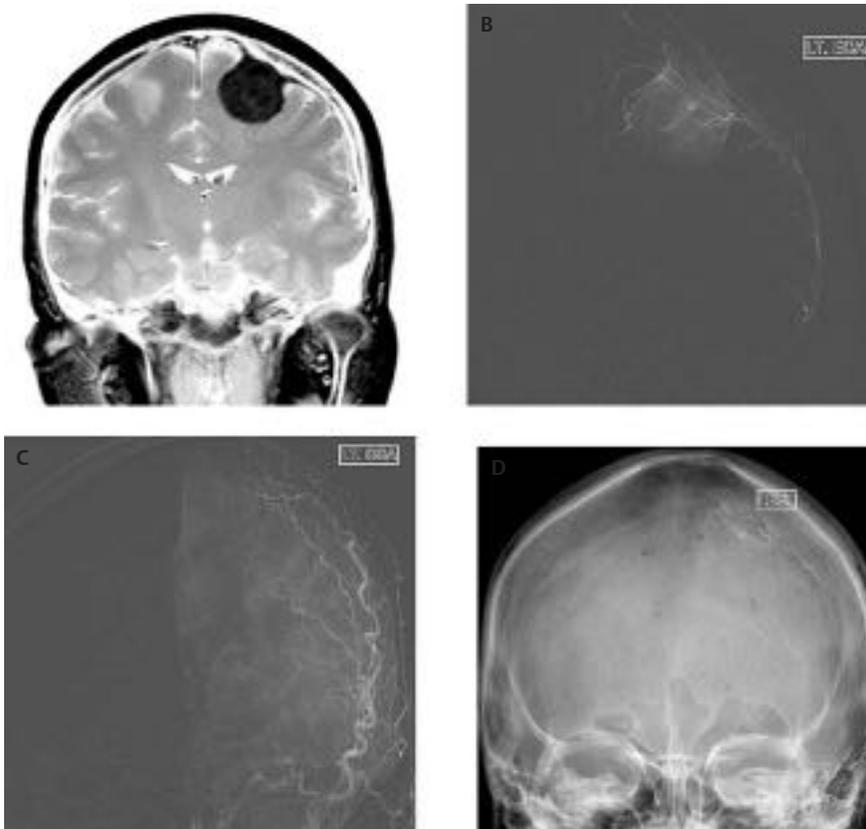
Left convexity meningioma. (A) Coronal magnetic resonance image. (B) Superselective left middle meningeal artery angiogram demonstrating the hypervascular mass in the late arterial phase. (C) Anteroposterior (AP) left external carotid artery angiogram demonstrating the absence of tumor blush following embolization with n-butyl cyanoacrylate (nBCA). (D) AP fluoroscopic image demonstrating the glue cast in the distal left middle meningeal artery. nBCA was utilized to embolize this tumor due to its distal location, far from the skull base foramina and exiting cranial nerves.
